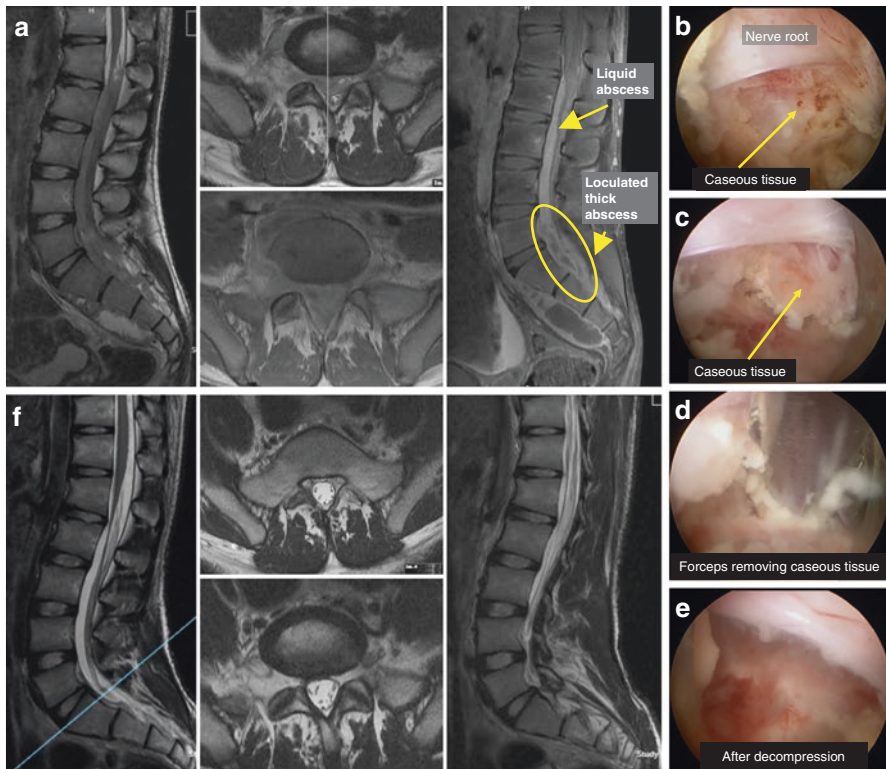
(a) Preoperative MRI pictures showing extensive ventral epidural abscess from mid sacrum to T12-L1 junction. (b) Endoscopic picture showing caseous tissue under the nerve root. (c) Another Endoscopic picture of caseous tissue under nerve root. (d) Forceps removing the caseous tissue. (e) After complete removal of infected material with well decompressed nerve root. (f) Three months postoperative MRI showing complete resolution of abscess with undamaged disc and paraspinal structures. (g) Intraoperative clinical photo showing tilting of the endoscope to access the upper part of thickened abscess. (h) Intraoperative fluoroscopy photo showing the tip of flexible probe reaching lower border of L4 vertebra
